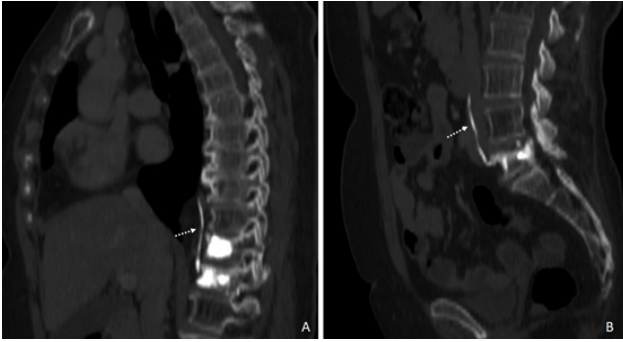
Reconstructed oblique sagittal plane venous phase contrast-enhanced CT (bone window) with high-density material filling the vertebral bodies of T11 and T12 and within the azygos vein (A, dashed arrow) and filling the vertebral body of L5 and within the left common iliac vein and the inferior vena cava (B, dashed arrow) indicating bone cement venous leakage.
